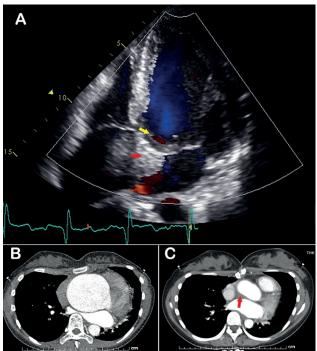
(A) postoperative echocardiographic imaging of the apical five-chamber view. Yellow arrow indicates mechanical valve, red arrow indicates thrombosis surrounding prosthesis; (B) and (C) pre- and postoperative enhanced computer tomography scan of the same patient. Red arrow indicates thrombosis surrounding prosthesis.
